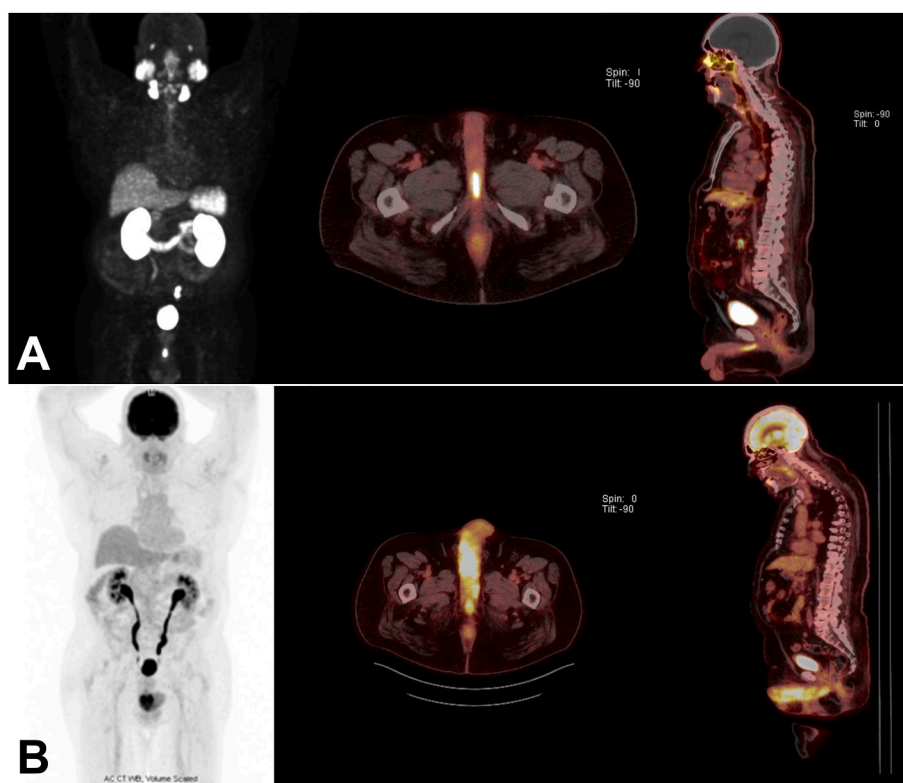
(A) 68Ga-PSMA PET coronal, axial and sagittal views demonstrating no abnormal heterogenous and (B) 16F-FDG-PET coronal, axial and sagittal views demonstrating abnormal heterogenous uptake throughout the penis, without other avid areas.
